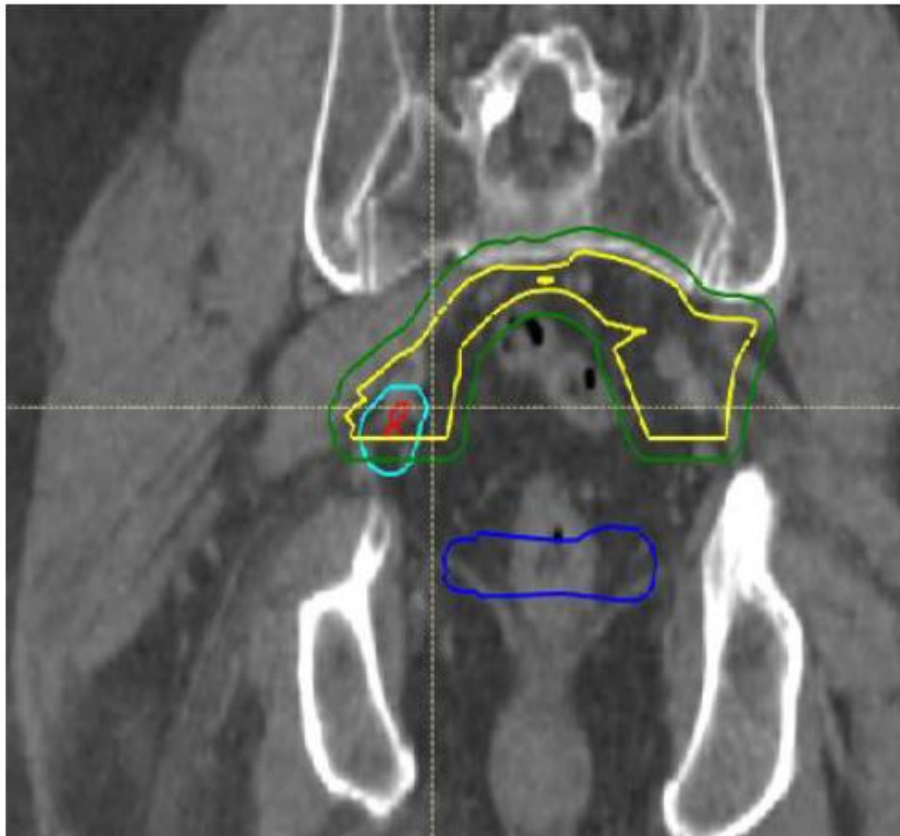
Coronal planning CT image demonstrating the previous prostatic fossa PTV (blue) and the Pointer-PC CTVpelv (yellow) and PTVpelv (green). A 1 cm gap between the caudal aspect of PTVpelv and cranial aspect of the previous prostatic fossa PTV is shown.
